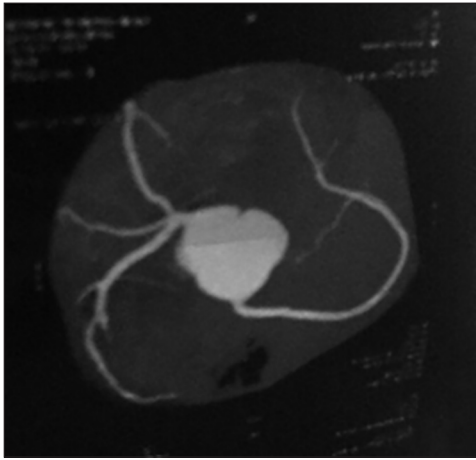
CT Angiography 24 h later showing normal coronaries
